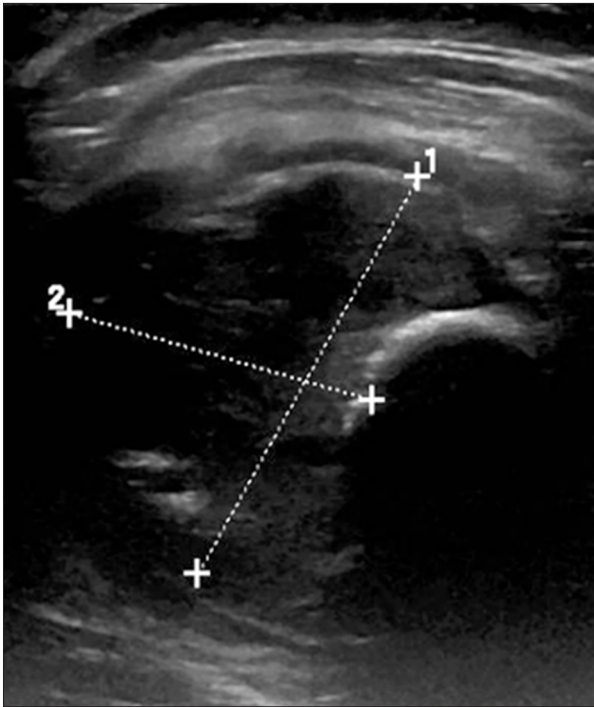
Ultrasound image showing the mass as a hypoechoic lesion with foci of calcification.
